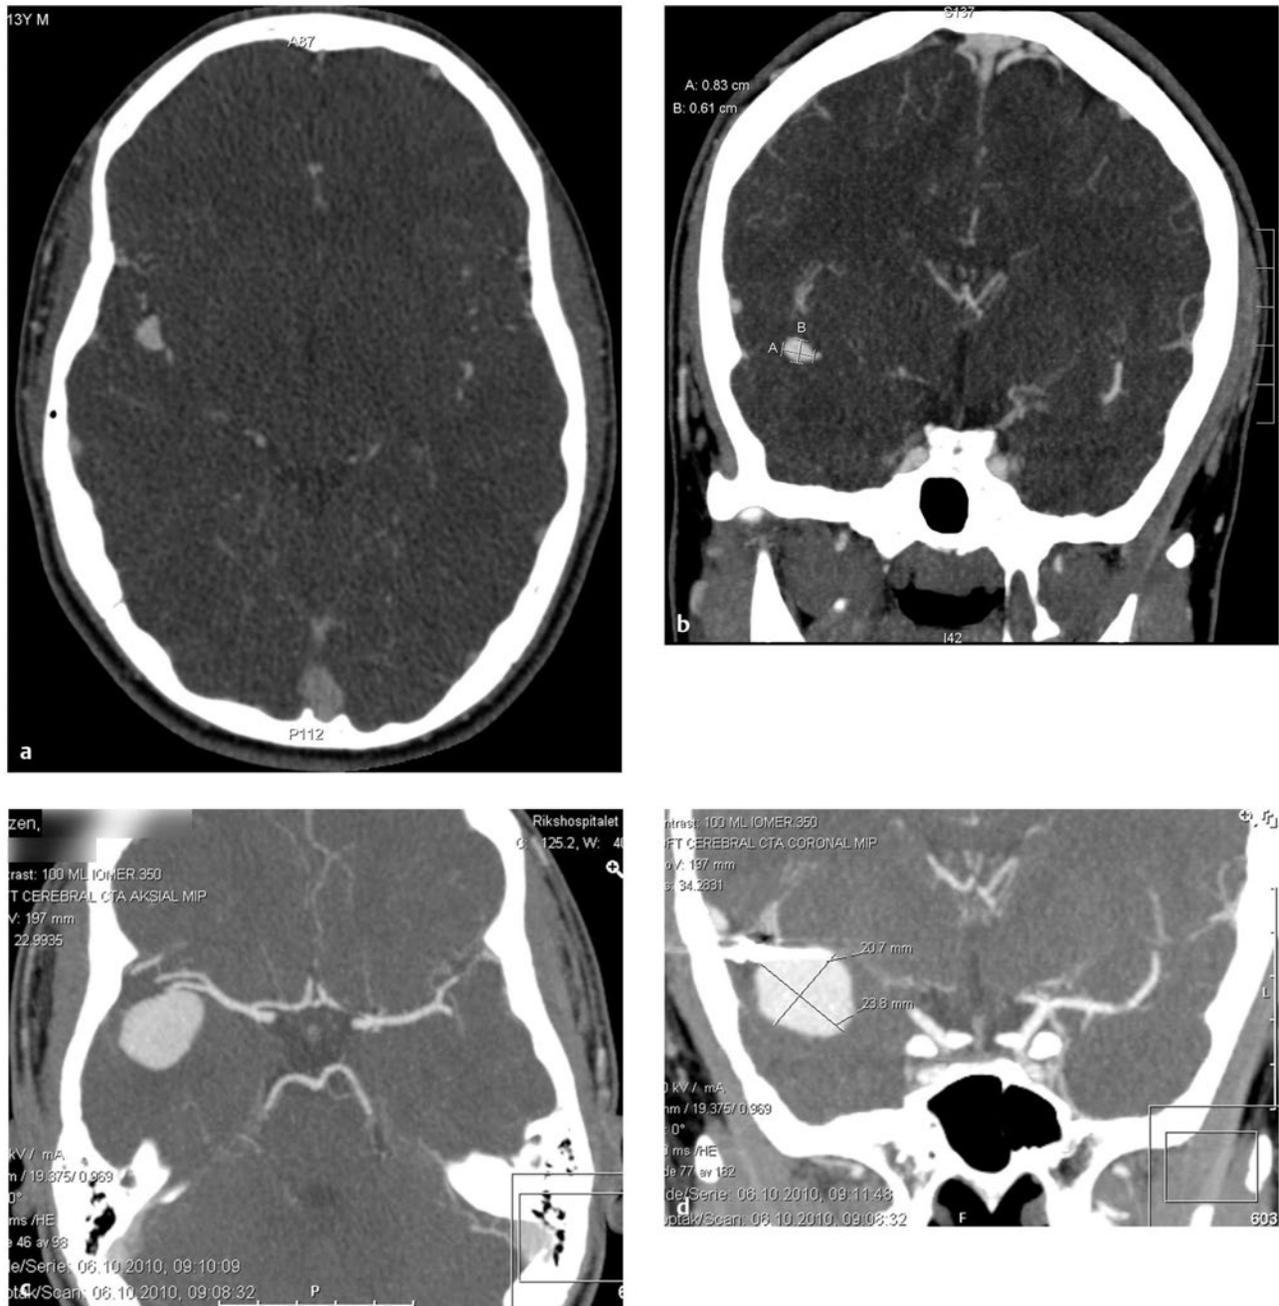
This 15-year-old boy presented with a recurrent, giant distal middle cerebral artery (MCA) aneurysm. (a,b) He had presented 2 years earlier with a small MCA aneurysm arising from a bifurcation in the superior division of the MCA along the insular M2 segment. He underwent right pterional craniotomy and direct clipping in Norway, with no surgical complications. (c,d) Follow-up revealed aneurysm recurrence with marked enlargement, (e,f) as seen on computed tomographic angiography (*continued*)
